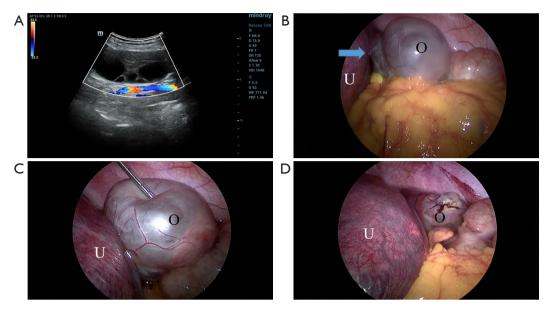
Laparoscopic treatment of ovary torsion in a twin pregnancy at 16 weeks. (A) Color Doppler ultrasonography showing an enlarged ovary with multiple compartments. (B) The enlarged ovary was twisted by one cycle (arrow) and had turned purple. (C) Puncture and vacuuming of the cyst fluid. (D) The recovered ovary after bipolar coagulation hemostasis. O, ovary; U, uterus.
